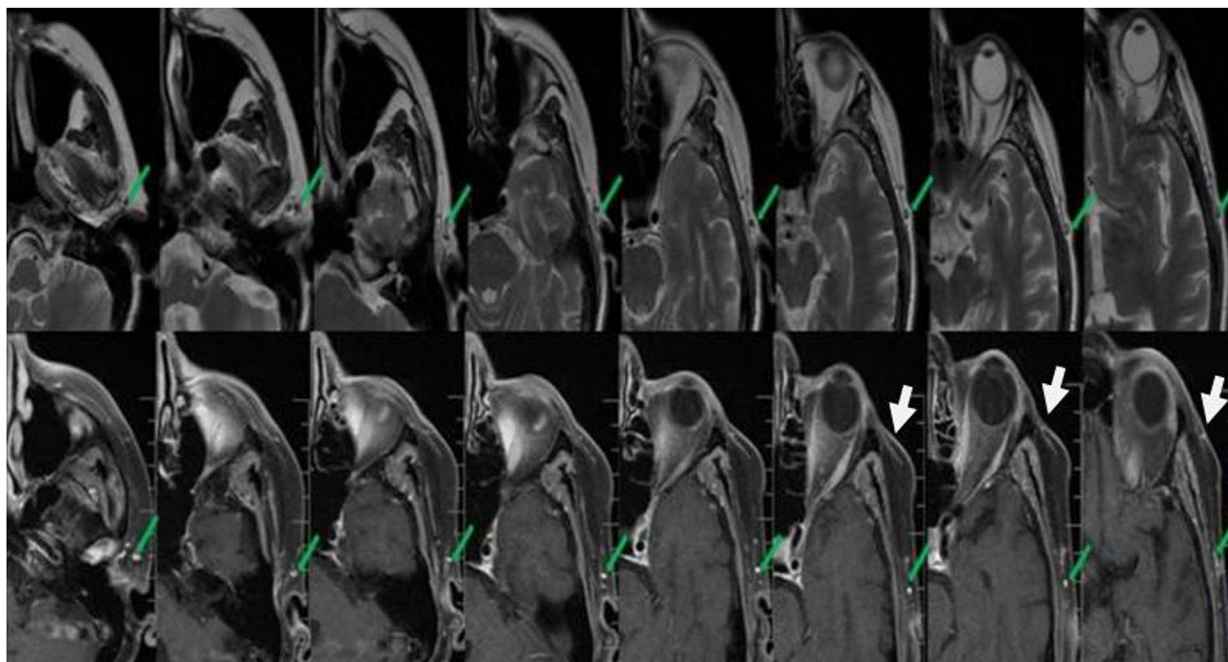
The preoperative axial T2 magnetic resonance imaging (MRI) (top row) tracing the origin of the vessel up to the area of the superficial temporal artery biopsy (TAB) site and postoperative T1 postcontrast axial MRI show that at the site of the left TAB, there is a reduction in the thickening of the previously enhancing temporal artery wall (green arrow) and some residual surrounding soft-tissue edema caused by postoperative changes from the left-sided TAB (white arrow).
